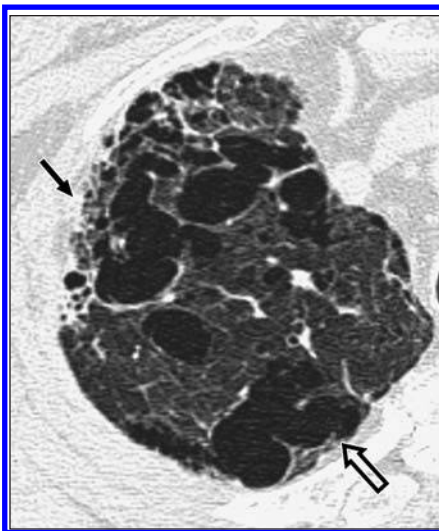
Ankylosing spondylitis. Transverse CT image of chest shows apical fibrobullous disease that includes subpleural fibrosis (solid arrow) as well as bullous changes (open arrow).
